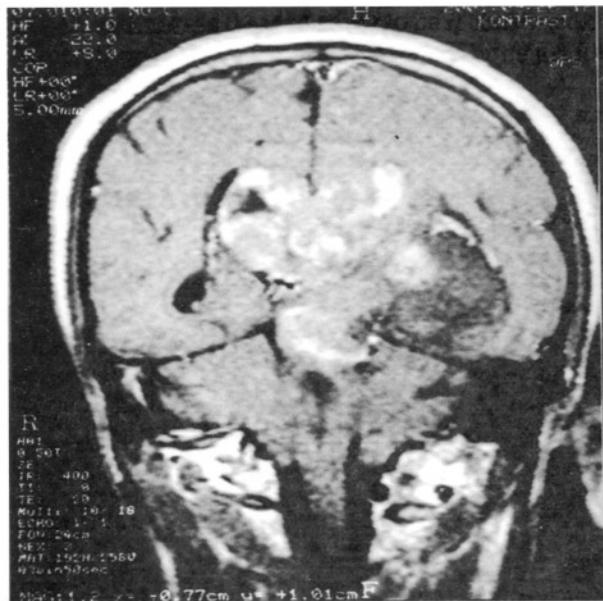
T1-weighted coronal magnetic resonance imaging of the large biventricular tumor.
